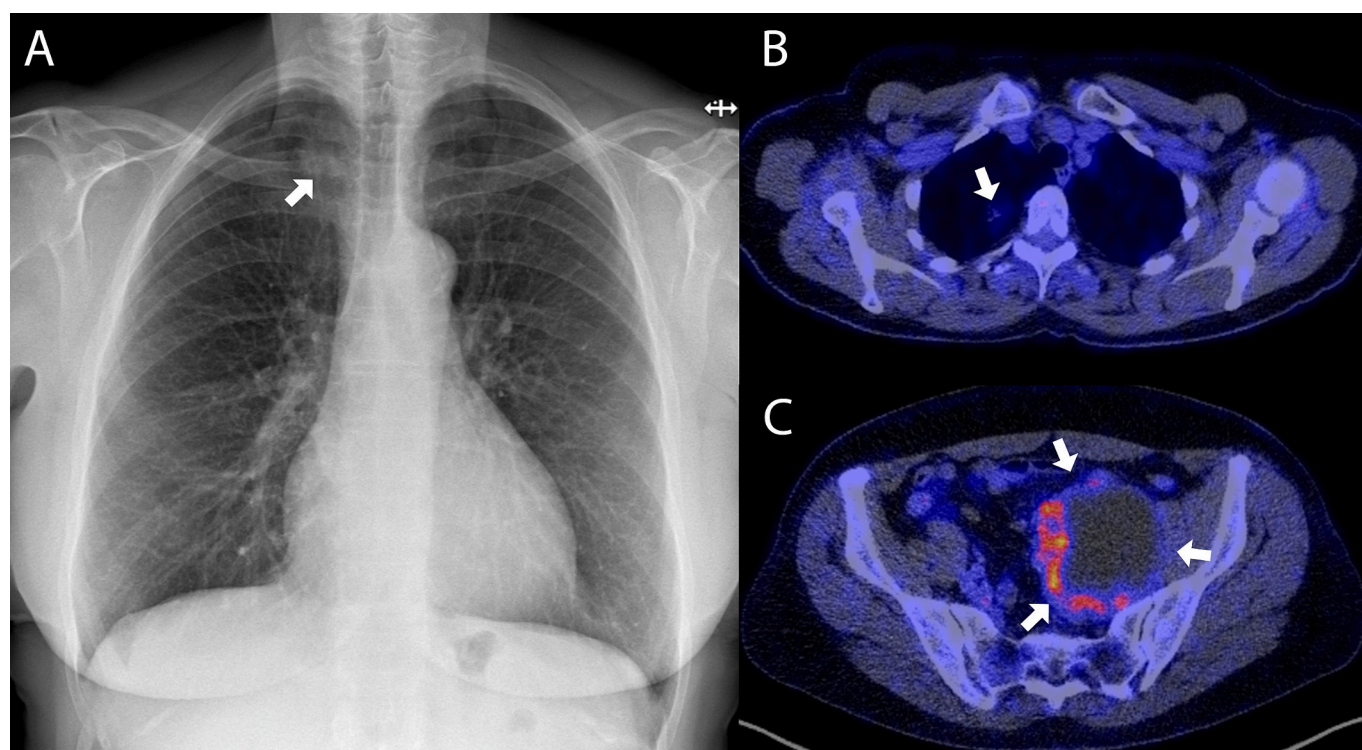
A 74-year old female in whom a 22x19x15 mm pulmonary lesion was incidentally found on routine chest radiography before aortic valve replacement (A, arrow). This pulmonary lesion turned out to be metabolically inactive on FDG-PET/CT (B, arrow). However, FDG-PET/CT showed a cystic, partly FDG avid tumor in the pelvis (C, arrows) as a new incidental finding. Abdominal CT and MRI were performed, followed by explorative laparotomy with radical excision and unilateral ovariectomy. Pathological examination demonstrated a schwannoma without malignant characteristics. The surgery led to damage of the sciatic nerve (confirmed with electromyography) with permanently decreased strength and sensibility in the left leg.
